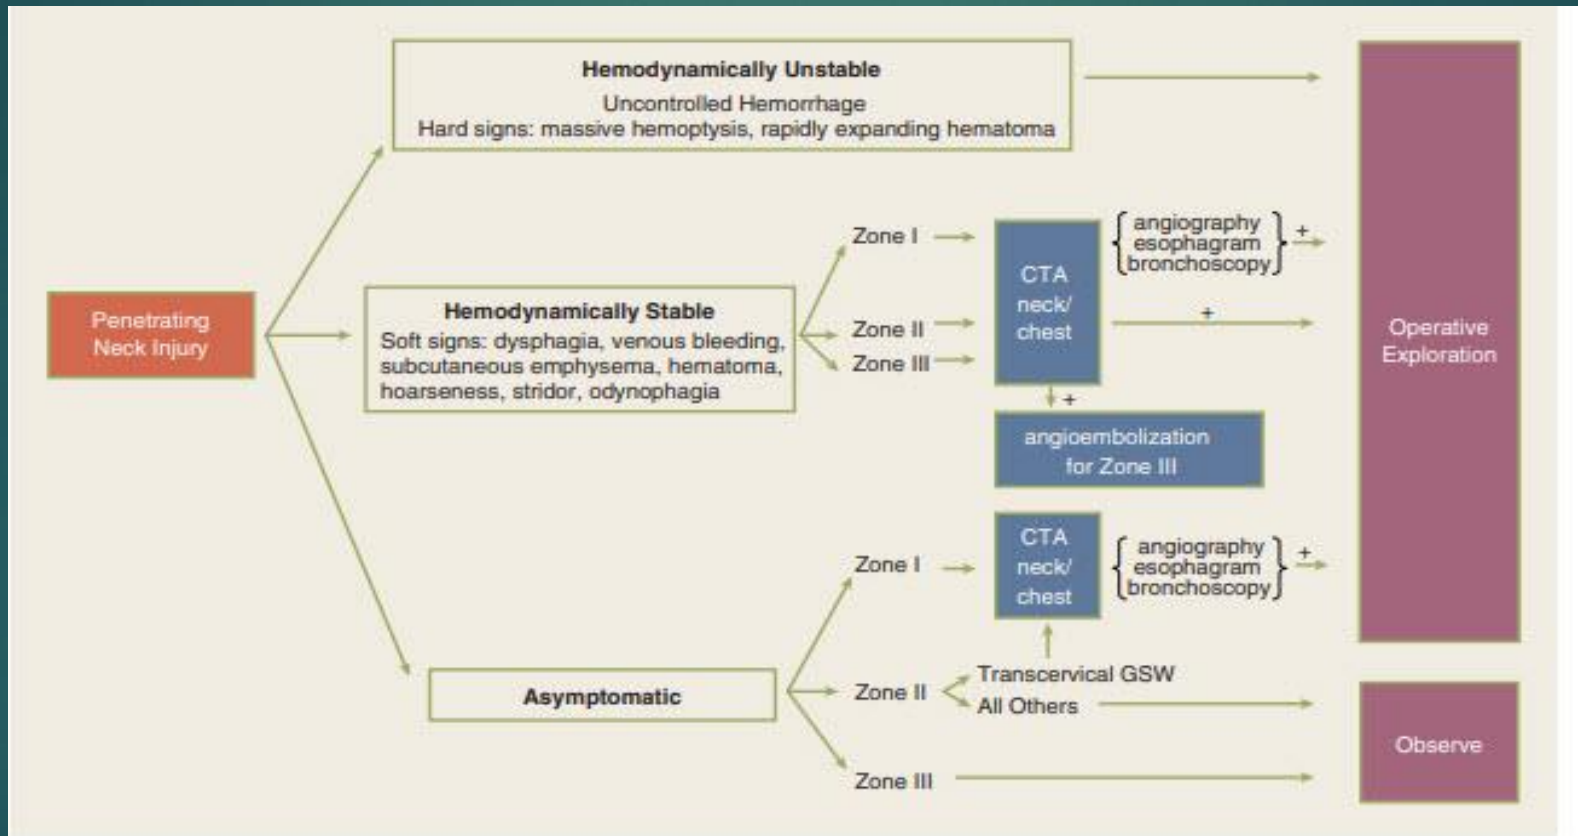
Algorithm for the management of penetrating neck injuries. CTA = computed tomographic angiography; GSW = gunshot wound.
